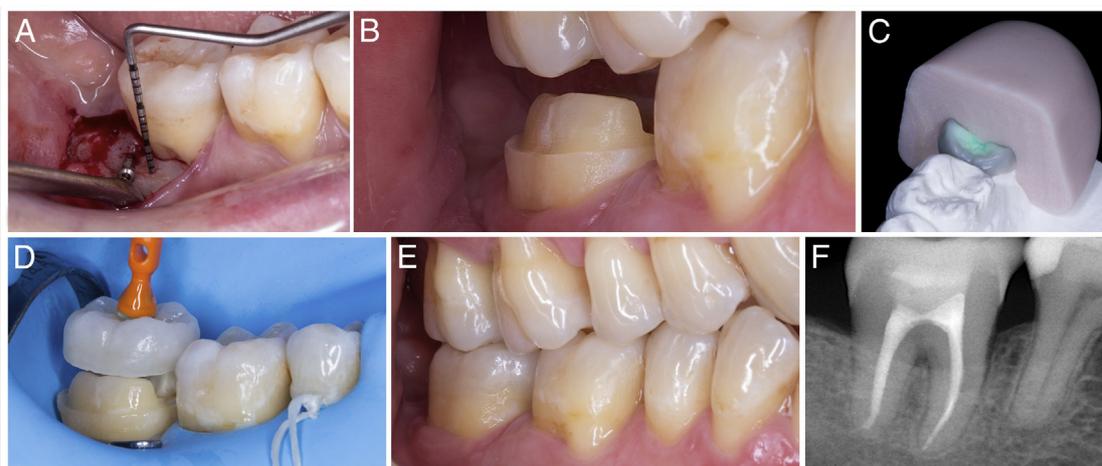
(A) Removal of the osteosynthesis screw. Note the bone regeneration obtained throughout the vestibular area. (B) Details of the overlay preparation of the transplanted tooth. (C) The laboratory painted lithium disilicate wax-up. (D) Try-in and small occlusal check of the restoration without rubber dam isolation. (E) Lithium disilicate painted overlay after the adhesive cementation. (F) The 2-year radiographic follow-up showing normal bone contour around the tooth.
